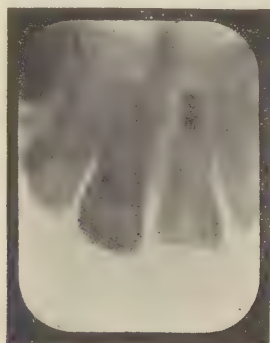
Radiograph of a fractured central incisor of a boy nine years old with the large foramen incident to his age closed with a measured gutta-percha cone and the remainder of the canal as yet unfilled.
